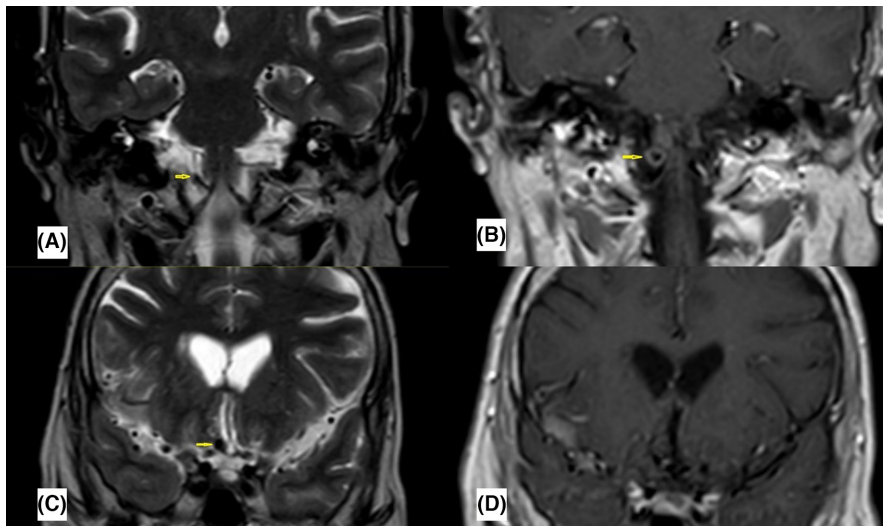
Coronal images of T2-weighted and T1-weighted MRI with gadolinium show (A, B) circumferential enhancement of the posterior inferior cerebellar artery aneurysm and (C, D) minimal enhancement of the ACom aneurysm.
